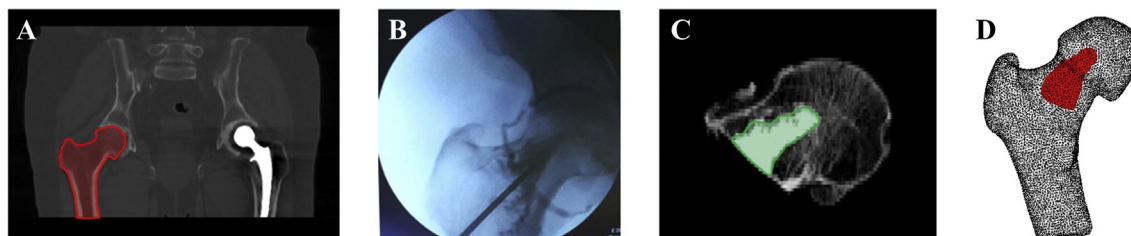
(A) Preoperative CT-scan with bone segmentation. (B) Intraoperative fluoroscope image. (C) Postoperative CT-scan of the femoral head and neck with biphasic material segmentation. (D) Final FE mesh of the femur with 10 ml injected material.
